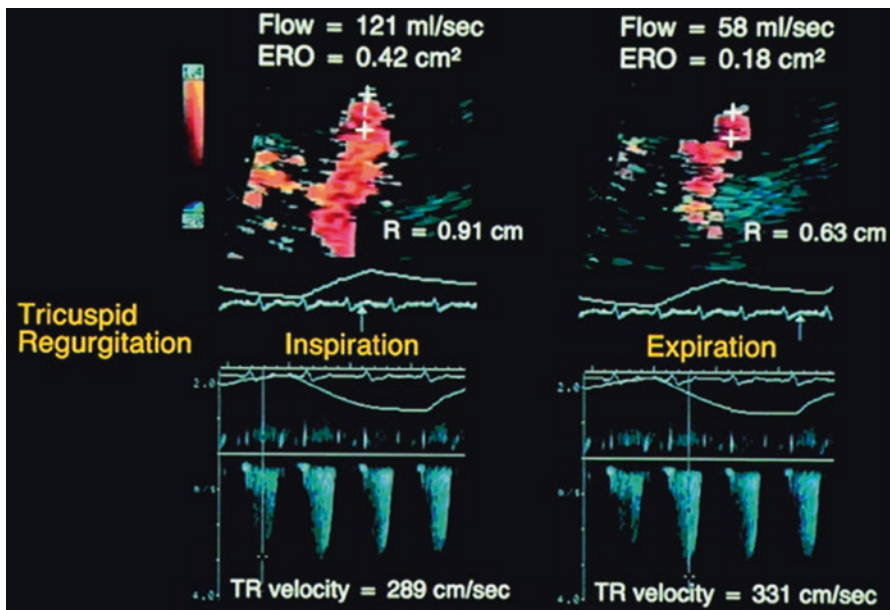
Impact of inspiration and expiration on the measurements of TR flow using the flow convergence method (*top*) and peak velocity using continuous-wave Doppler (V_{max} ; *bottom*) with calculation of ERO in inspiration (*left*) and expiration (*right*). Respirometer curves ascend with inspiration and descend with expiration. During inspiration, V_{max} decreases, regurgitant flow increases, and ERO increases considerably. Modified with permission from Topilsky et al. [32]
